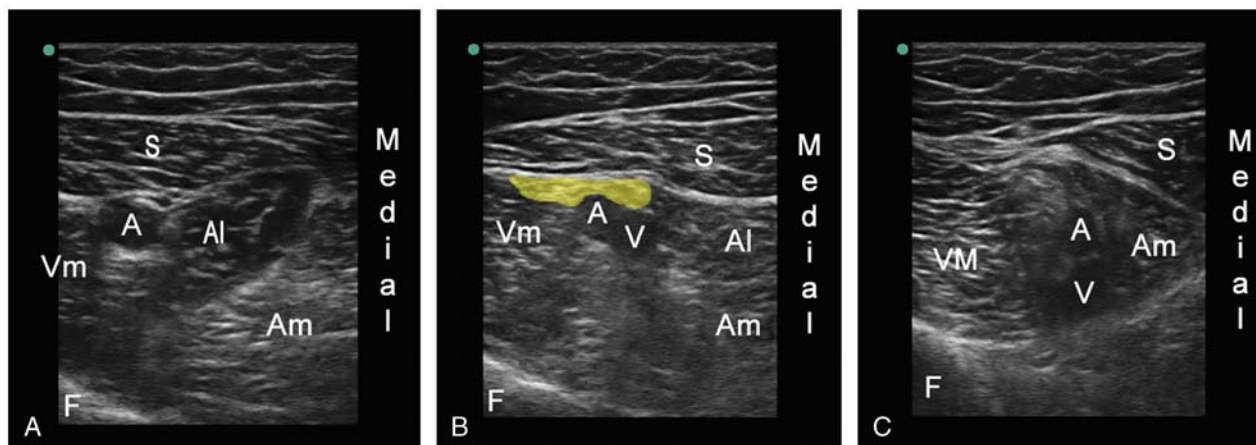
A, Axial ultrasound scan of the right thigh at the apex of the femoral triangle. Note the point of intersection of the medial borders of the sartorius and adductor longus muscles. A, Femoral artery; Al, adductor longus; AM, adductor magnus; F, femur; S, sartorius; VM, vastus medialis. B, Axial ultrasound scan of the right thigh in the mid-adductor canal. Note both adductor longus and magnus muscles are noticeable. The area shaded in yellow represents the most common location of the SN and NVM, anterolaterally to the femoral vessels. A, Femoral artery; Al, adductor longus; AM, adductor magnus; F, femur; S, sartorius; V, femoral vein; VM, vastus medialis. C, Axial ultrasound scan in the distal end of the right adductor canal. Note the adductor longus is no longer present at this level. The adductor magnus has a fibrous lateral edge corresponding to the adductor hiatus and the femoral vein has rotated and is posterior to the femoral artery in its passage to the popliteal fossa. A, Femoral artery; Am, adductor magnus; F, femur; S, sartorius; V, femoral vein; VM, vastus medialis.
